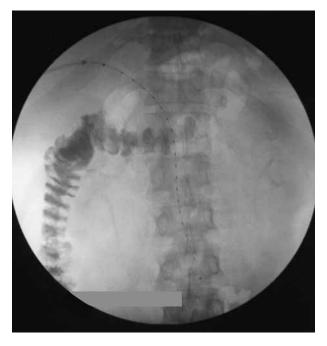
Plain abdominal x-ray shows the EKOS catheter within the superior mesenteric vein and portal vein. Note the multiple opaque transducers for ultrasound delivery along its working length.
